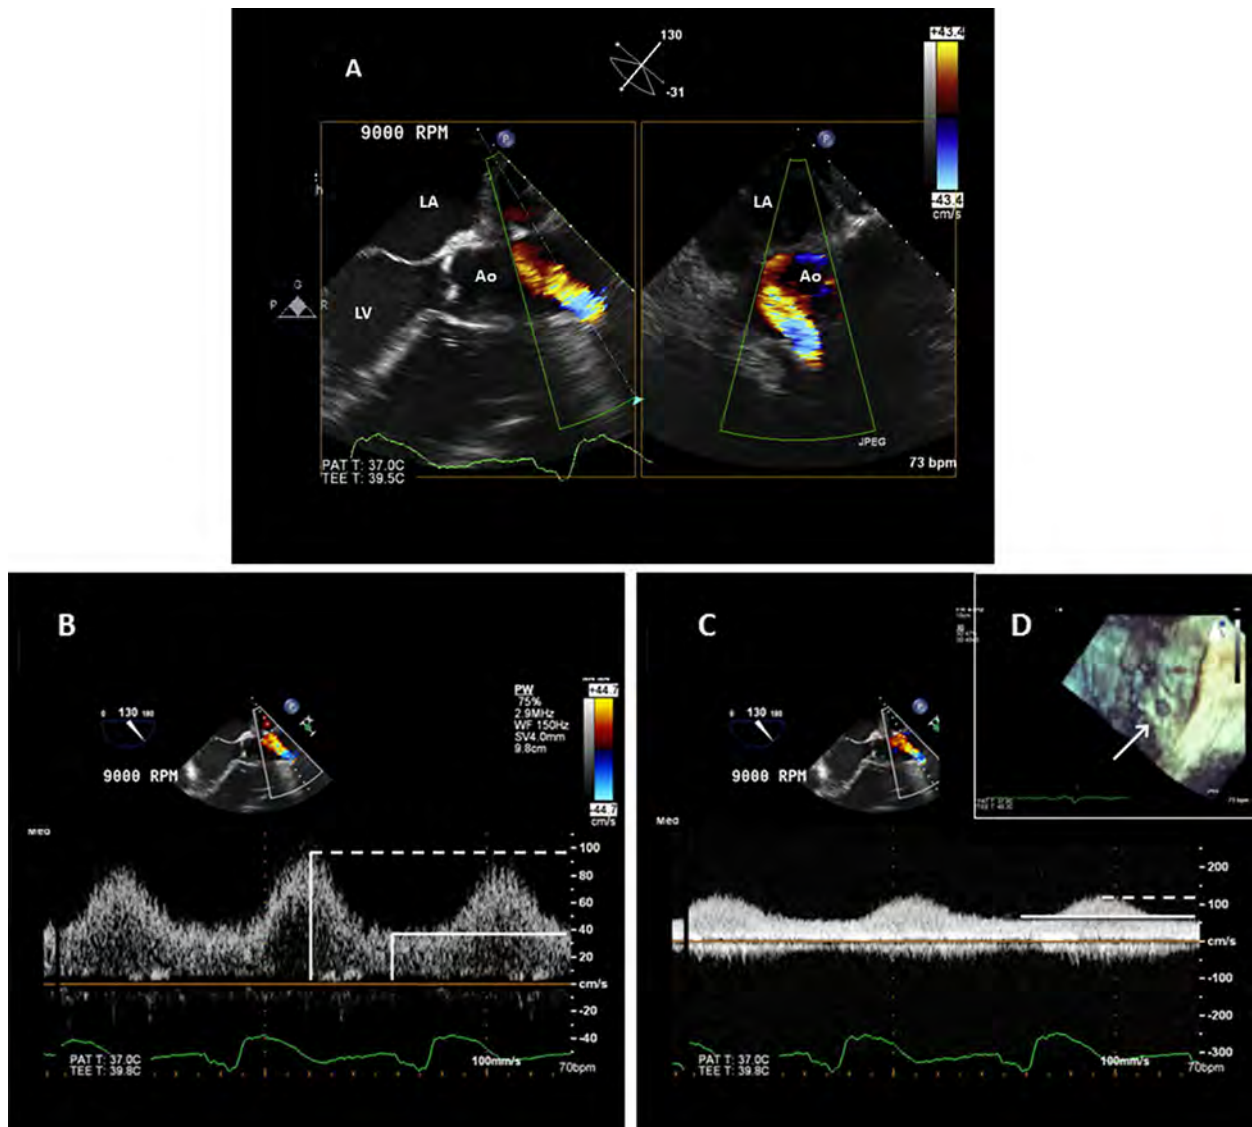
TEE of the outflow graft-to-ascending aorta anastomosis. (A) Simultaneous orthogonal plane 2D imaging with color-flow Doppler shows normal laminar color Doppler inflow. See also [Video 6](#). (B) Pulsed Doppler profile (peak velocity approximately 100 cm/s, dotted line). (C) Continuous-wave Doppler with a peak systolic velocity (dotted line) that, as expected, is somewhat higher (just >100 cm/s) than that revealed by pulsed Doppler. The solid line indicates the nadir diastolic velocity. (D) Typical circular appearance of unobstructed outflow graft-to-aorta anastomosis (arrow) using real-time 3D TEE, en face view.
